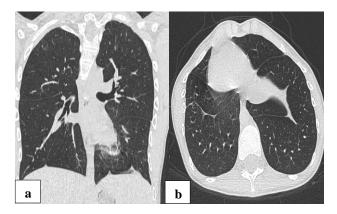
(a and b): CT images showing lung fibrosis.
